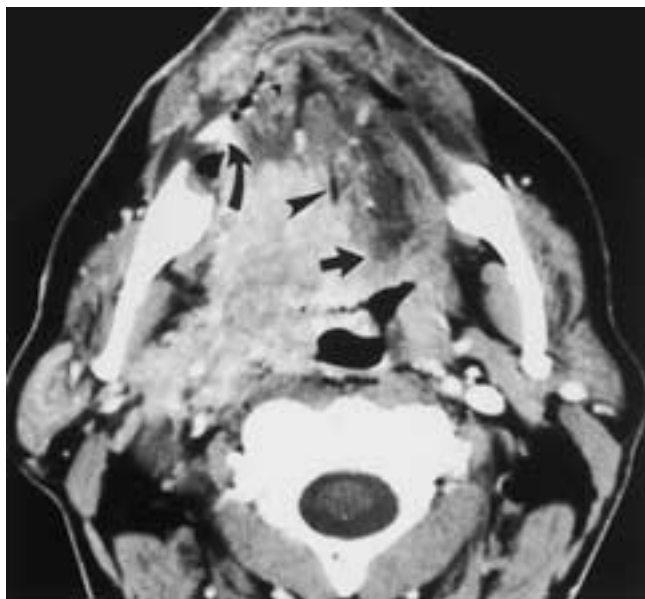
Squamous cell carcinoma. Axial CT scan with contrast demonstrates a large tumor involving the oral tongue and tongue base extending to involve the oropharynx, tonsillar fossa, carotid, and parapharyngeal spaces. The tumor clearly crosses the midline to involve the left tongue base (*straight arrows*). Extension anteriorly along the mylohyoid muscle and lateral floor of the mouth is present (*curved arrow*). The lingual septum is well visualized (*arrowhead*).
